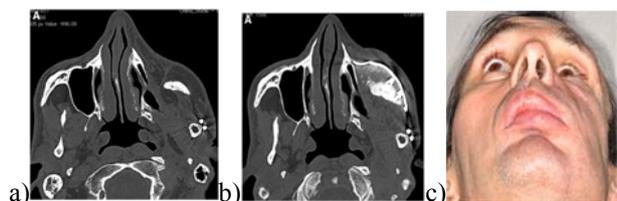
a) CT scan confirming the left zygomatic deficiency, b) Postoperative CT scan showing the restoration of the zygomatic bone, c) Patient after 4-month post-operative ^[18]
